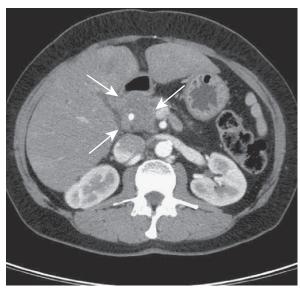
Computed tomography image of the same patient as in Figure 14.3 demonstrating probable invasion into the superior mesenteric vein by the pancreatic head mass (arrows).
